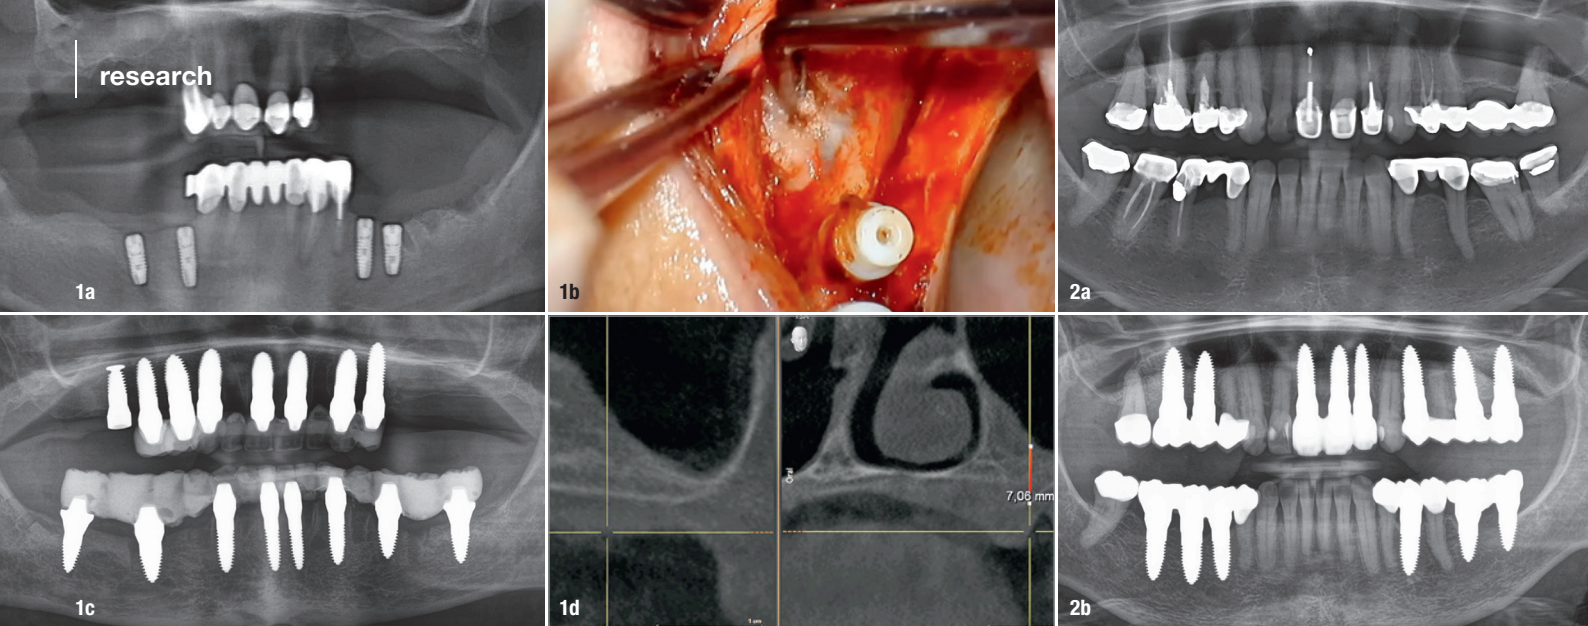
Pre-op panoramic radiograph showing obvious horizontal resorption of the sinus area in the second quadrant (a), intra-oral imaging of region #26 after applying the dome technique (b), post-op control of the implants in the upper and lower jaws after placing fixed temporary restorations (c), post-op CBCT scan of region #26 after a healing phase of six months, displaying a considerable gain of bone (d). Fig. 2: Pre-op panoramic radiograph with distinct horizontal resorption in region #26 (a), post-op control after implant placement and major external sinus floor elevation in region #26 (b).
